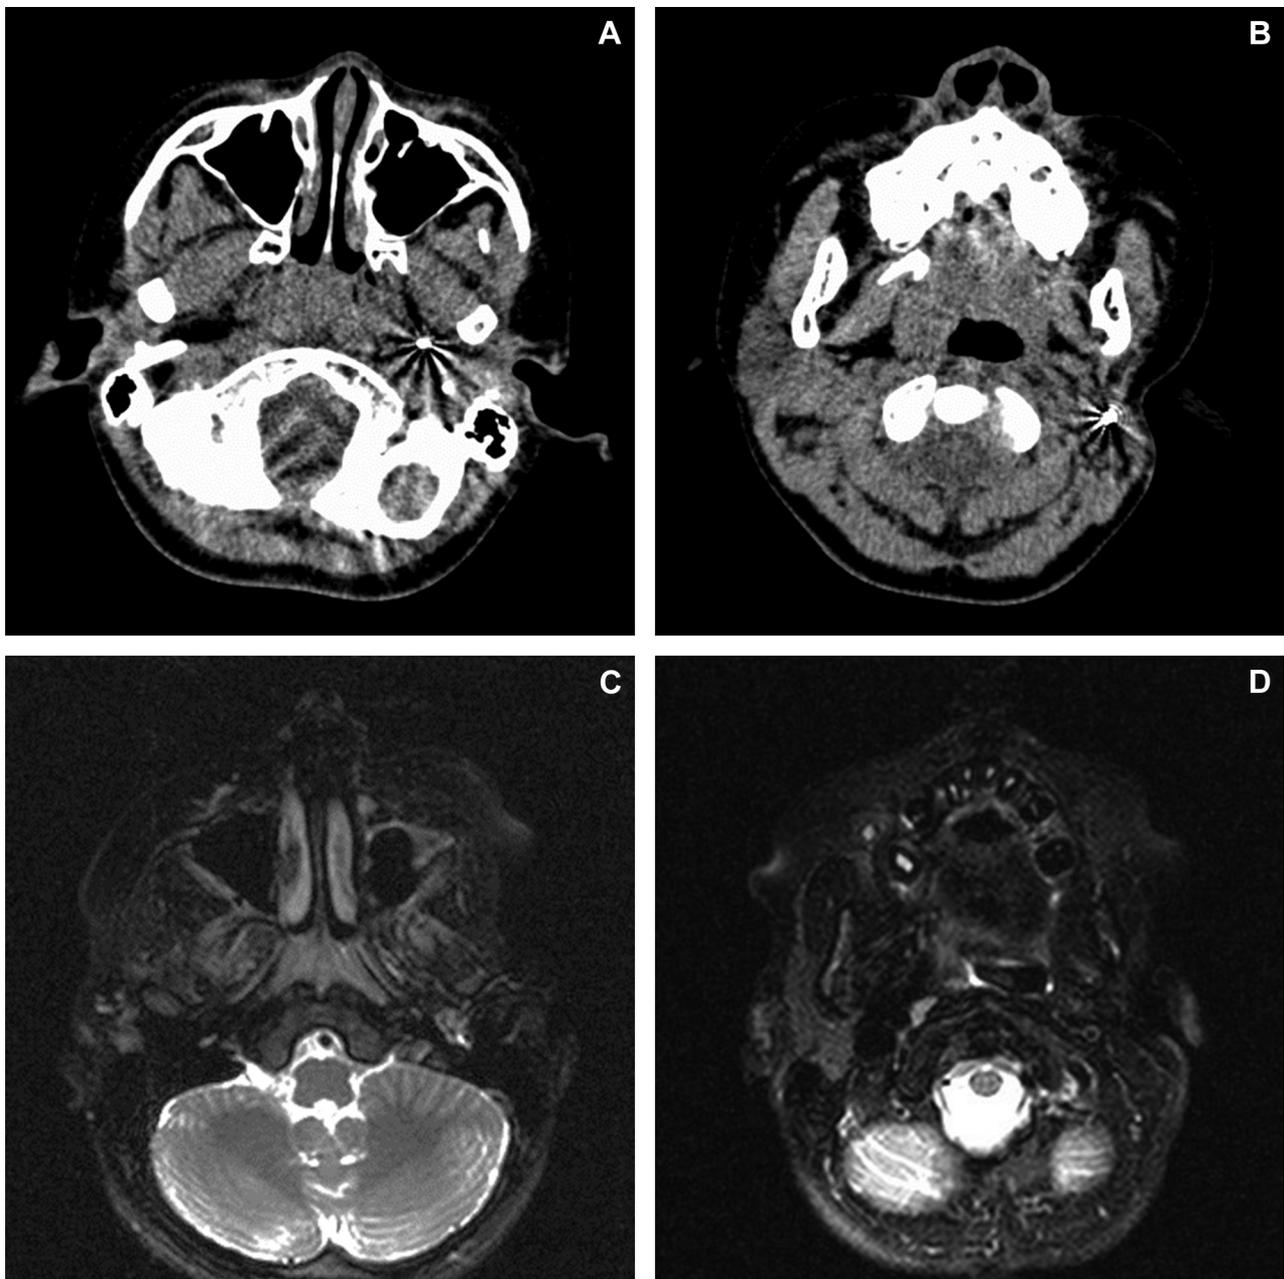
A, B, Computed tomograms show no sign of tumor 60 months after brachytherapy. C, D, Magnetic resonance images show no sign of tumor 60 months after brachytherapy.
